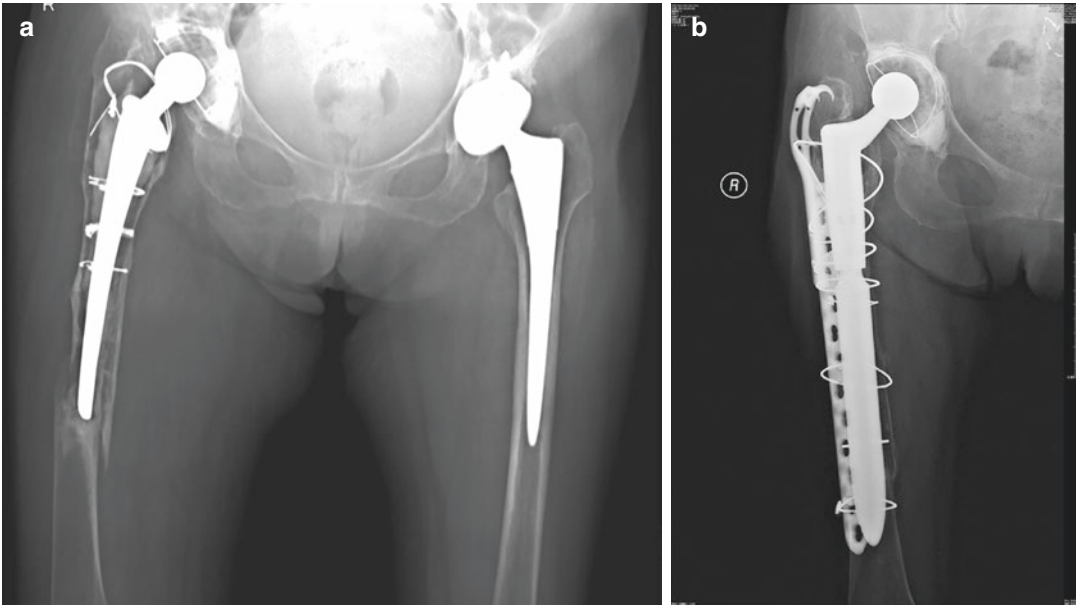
Radiograph of a periprosthetic femoral fracture type B3. (a) Preoperative image. (b) Postoperative image after revision arthroplasty and cable-plate fixation
